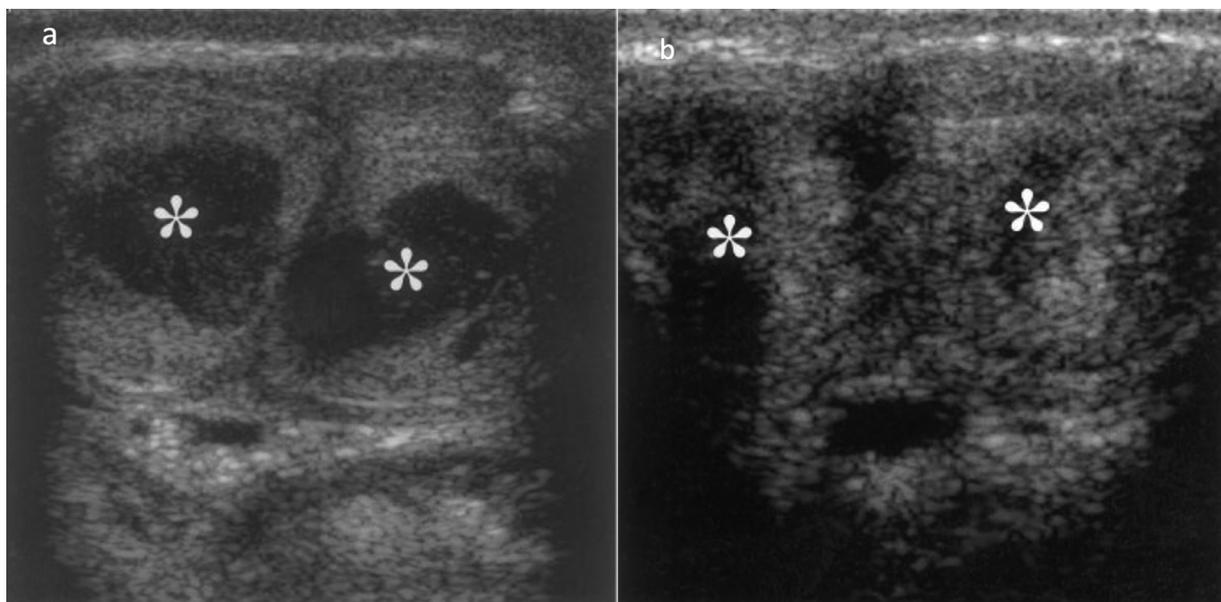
Circumscribed fibrosis secondary to high-flow priapism (a) Transverse ultrasonography displays bilateral cavernous hematomas (*) at the base of the penis (b) 6 months later, transverse ultrasonography displays inhomogeneity of corpora cavernosa due to fibrotic changes (*) Image used with permission from the Radiological Society of North America: Bertoloto M, et al. *RadioGraphics* 2003;23:495–503.
